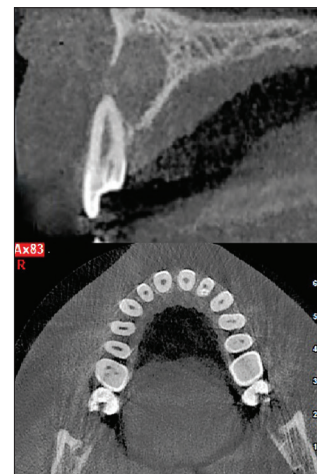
Cone-beam computed tomography (axial and sagittal views)
